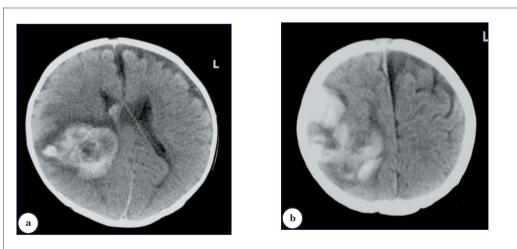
a) Axial brain CT showing large right parietal high attenuation lesion due to acute intracerebral hematoma with associated mass effect on the right lateral ventricle and mild midline shift towards the left side. Note the intraventricular bleeding in the right frontal horn. b) Axial brain CT showing extension of the acute intracerebral hematoma to the right frontal lobe.
